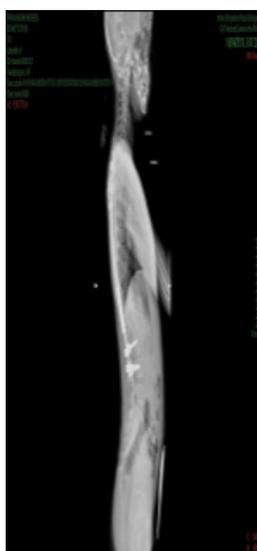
Postoperative radiographic picture after 3 lengthenings (Case 2).
